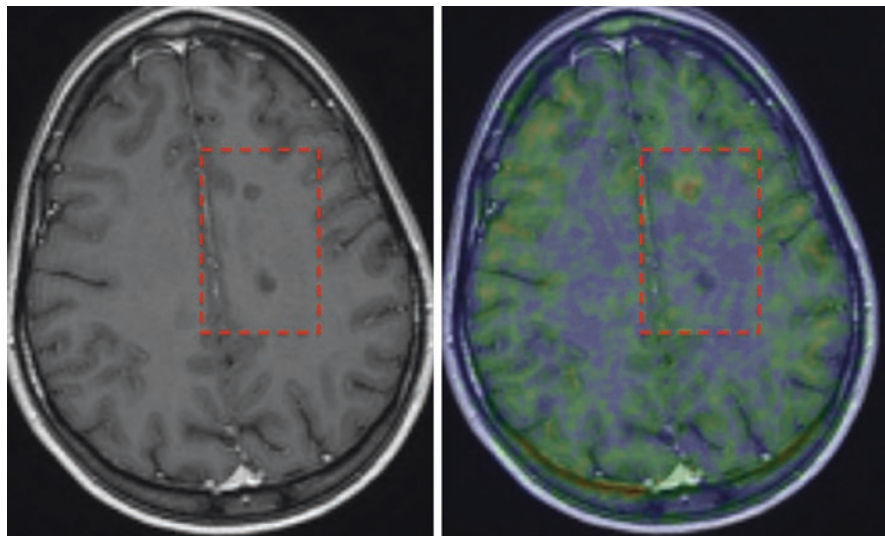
Differentiation of two non-enhanced lesions on T1 MRI and [^{11}C]PK11195 PET. The upper lesion clearly depicts an increase in [^{11}C]PK11195 uptake, which means inflammatory activation, and thus depicts an active lesion. In contrast, the lower lesion does not show increased tracer uptake, and therefore is an inactive lesion (permission for the use of the images was obtained; source: DOI: <https://doi.org/10.1007/s40336-015-0147-6>) (Airas et al. 2015)
